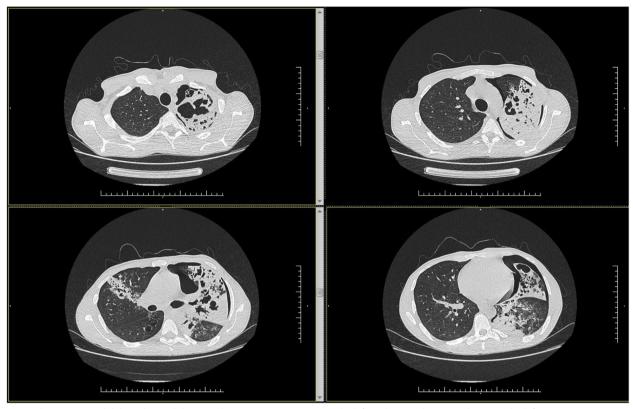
Thorax CT reveals bilateral consolidation with cavities, more intense on the left, and minimal pneumothorax on the left
